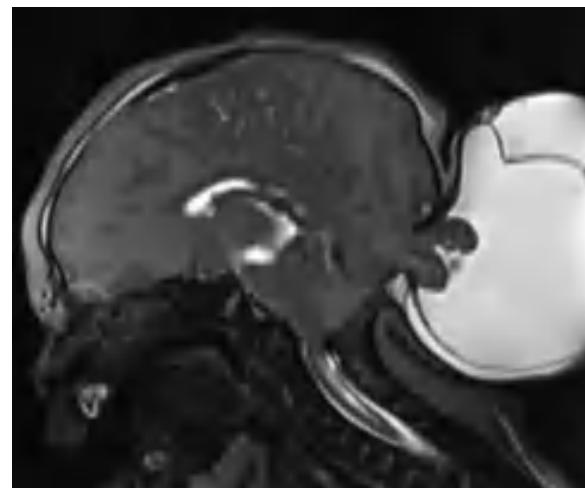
Occipital encephalocele. Sagittal T2-weighted MRI of a newborn with prenatally diagnosed cephalocele demonstrates encephalomalacic brain protruding through an occipital skull defect with entrapped CSF in the cephalocele sac representing a mixture of subarachnoid (deep) and subdural (superficial) fluid. Note that the intracranial subarachnoid spaces (e.g., basal cistern) are contracted because of the large extracranial CSF reservoir.
